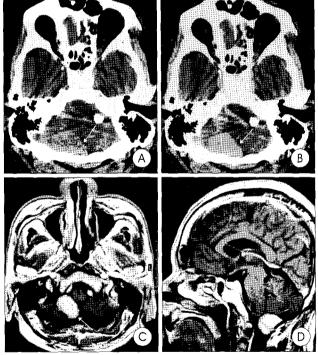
Preoperative brain computed tomography (A, B) and magnetic resonance image (C, D) reveal a strongly enhancing homogeneous mass (arrow) near the right side of foramen magnum. The most likely preoperative diagnosis, based upon this image, is meningioma.
